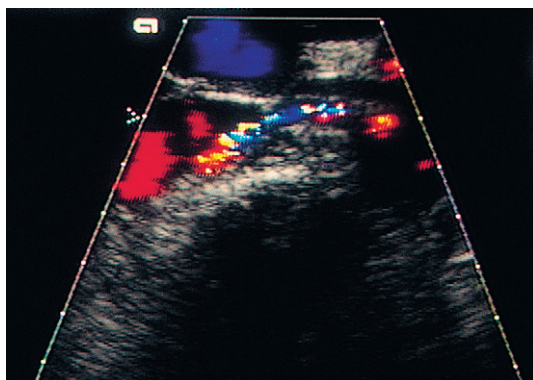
Colour flow Doppler of the origin of the right renal artery in a patient with renal artery stenosis. There is significant disturbance of the flow with a mosaic pattern within the colour signal.
